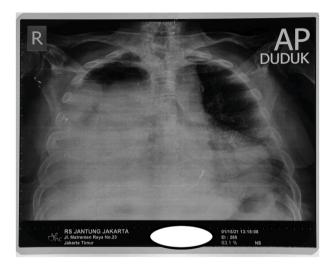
Patient chest X-ray on admission showed massive right pleural effusion.
